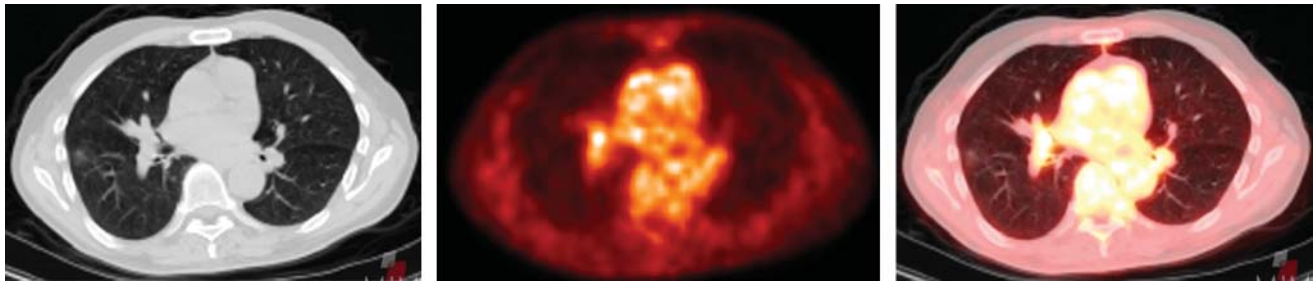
Ground-glass opacity in peripheral right lung. Mild ^{18}F -FDG activity is associated with this lesion.
